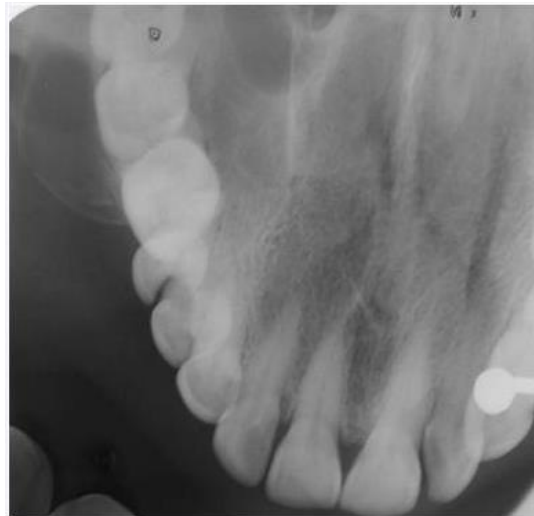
The maxillary occlusal radiograph showed thinning of the buccal cortex
